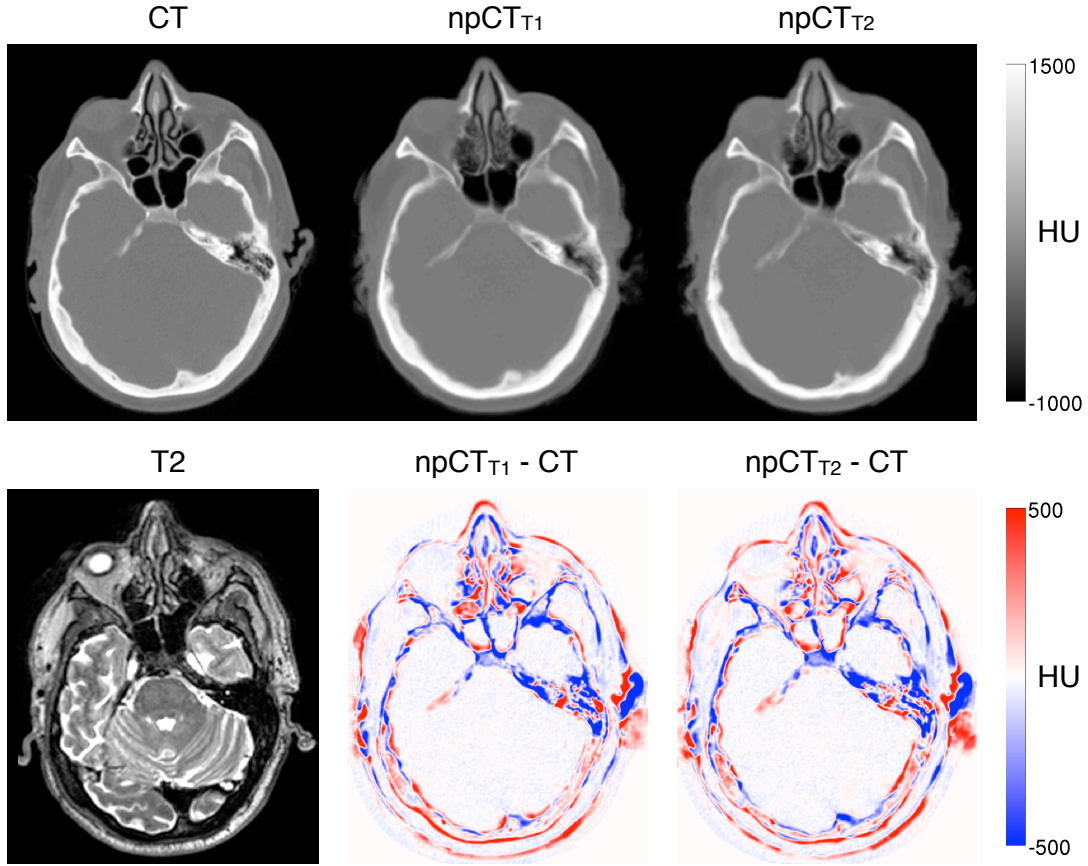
For a representative subject, the reference CT, the pseudo CTs synthesised from a T1-w (npCT_{T1}) and a T2-w (npCT_{T2}) MR image (top); and the acquired T2 and difference images between the pseudo CTs and the reference CT (bottom).
